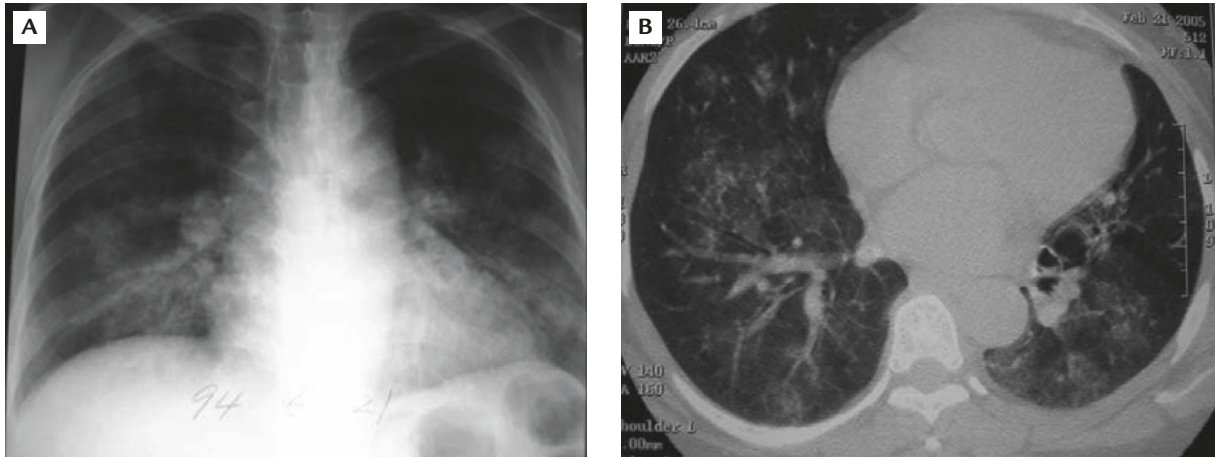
(A) Chest radiography shows bilateral lower lobe consolidation. (B) Chest computed tomography shows multiple patches of ground-glass infiltrates in both lung fields.
